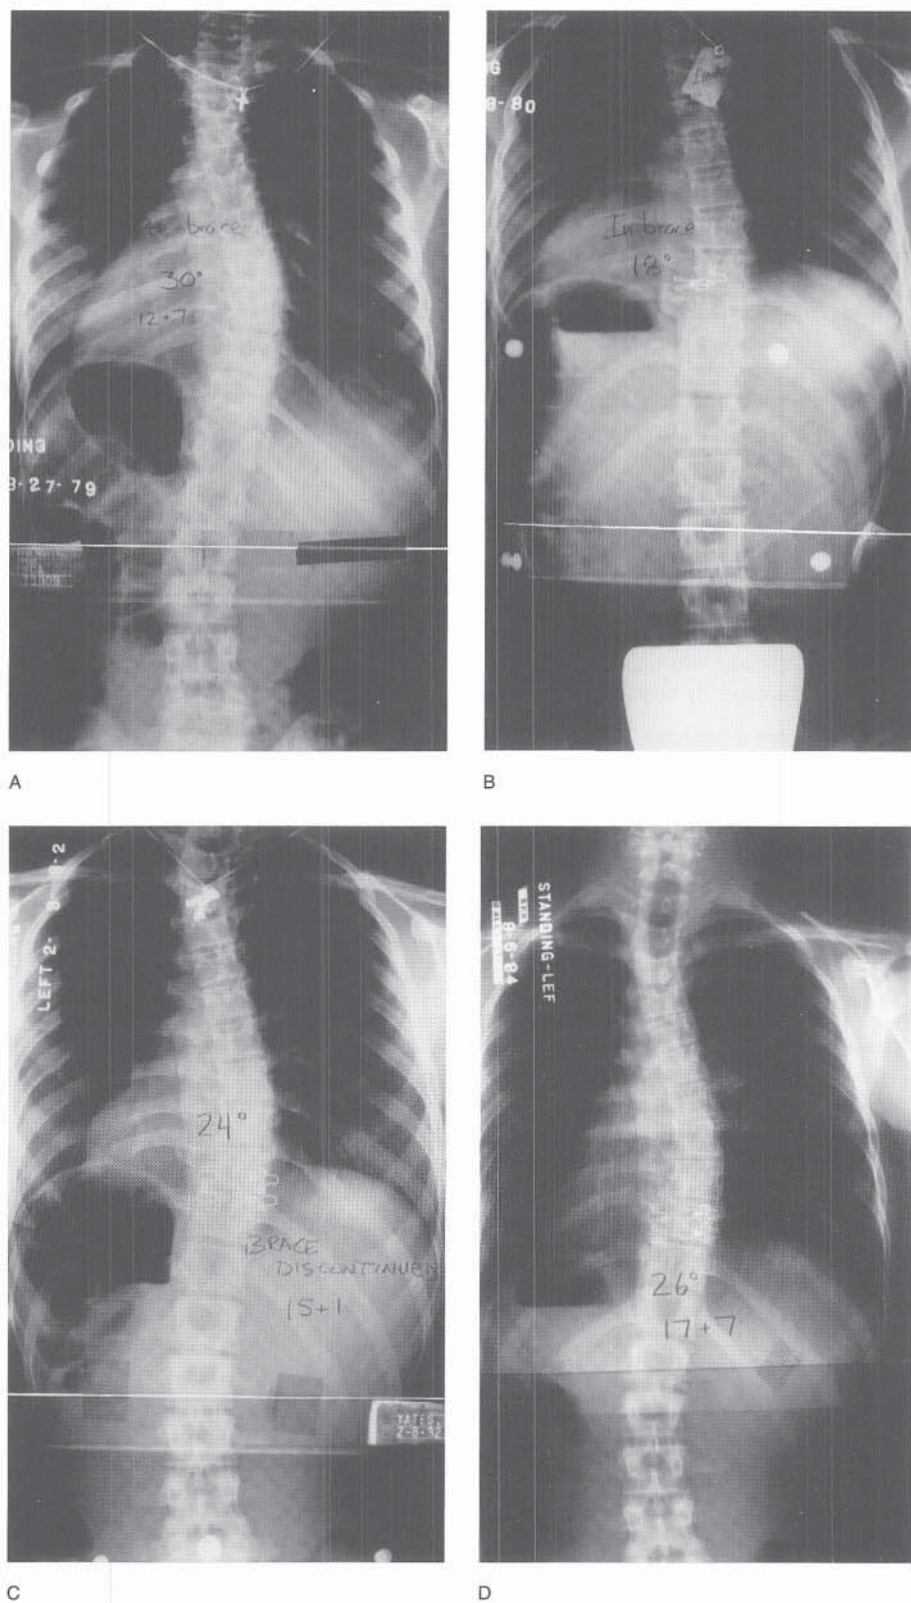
Radiographic findings with brace wear in a premenarchal girl age 12 years 7 months. A, Initially she had a 30-degree thoracic curve. Her Risser sign was 0. B, Treatment in a Boston brace was begun, with in-brace correction to 18 degrees. C, Brace wear was continued until the patient was 2 years postmenarchal and had a Risser sign 4. D, Two and one-half years later, the curve remained stable at 26 degrees.
